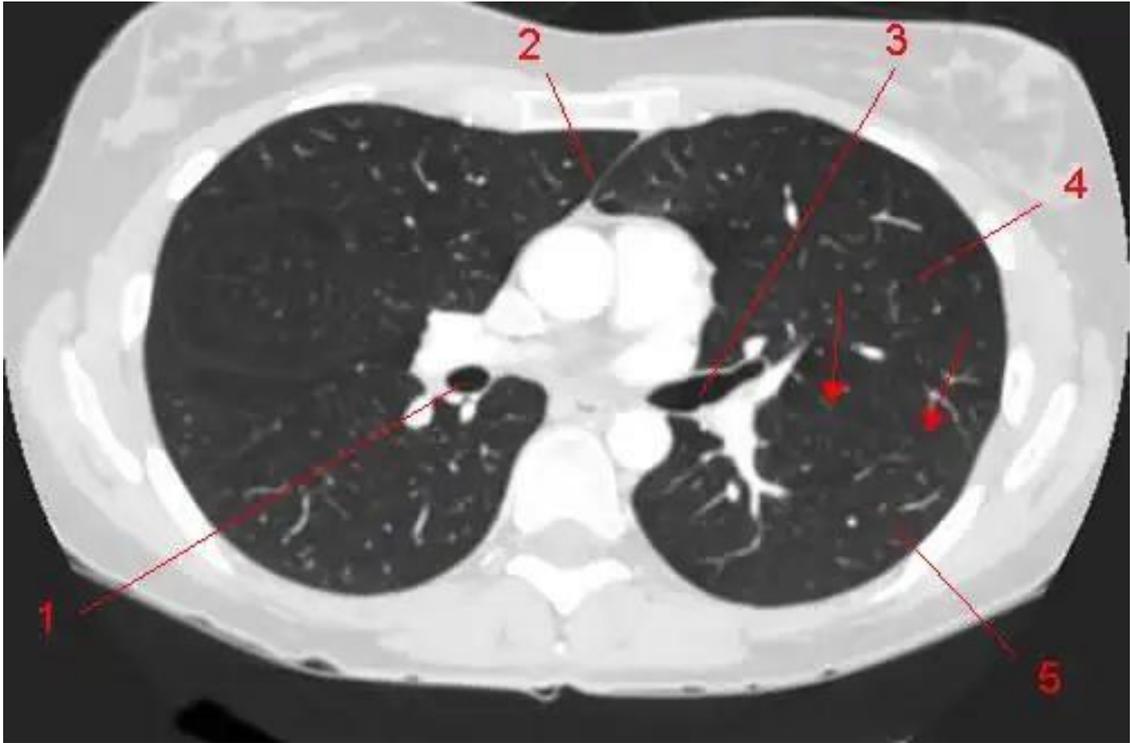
Axial reconstruction in pulmonary window depicting the CT anatomy of lungs. 1, Bronchus intermedius; 2, Anterior junction line; 3, Left main bronchus; 4, Superior segment of left upper lobe; 5, Left lower lobe; Red arrow, Major fissure.
